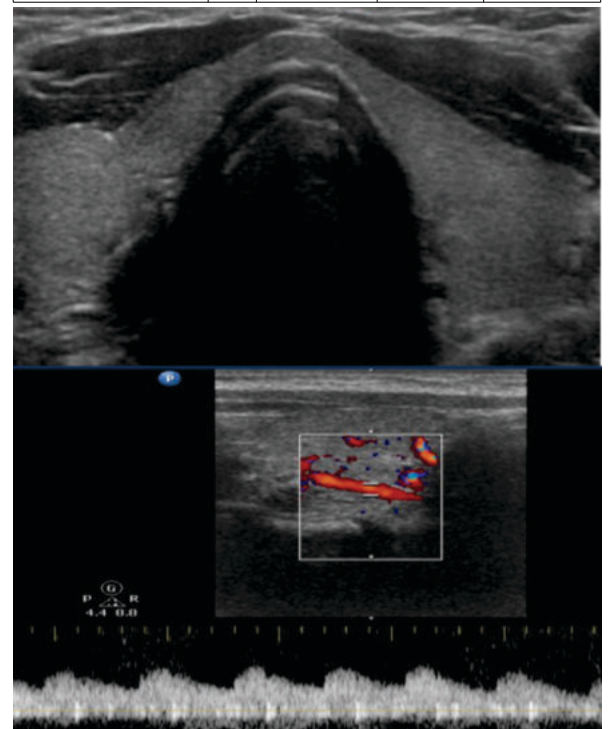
Gray scale appearance and Doppler evaluation of thyroid gland in normal individuals. Homogenous echotexture of normal thyroid gland.
